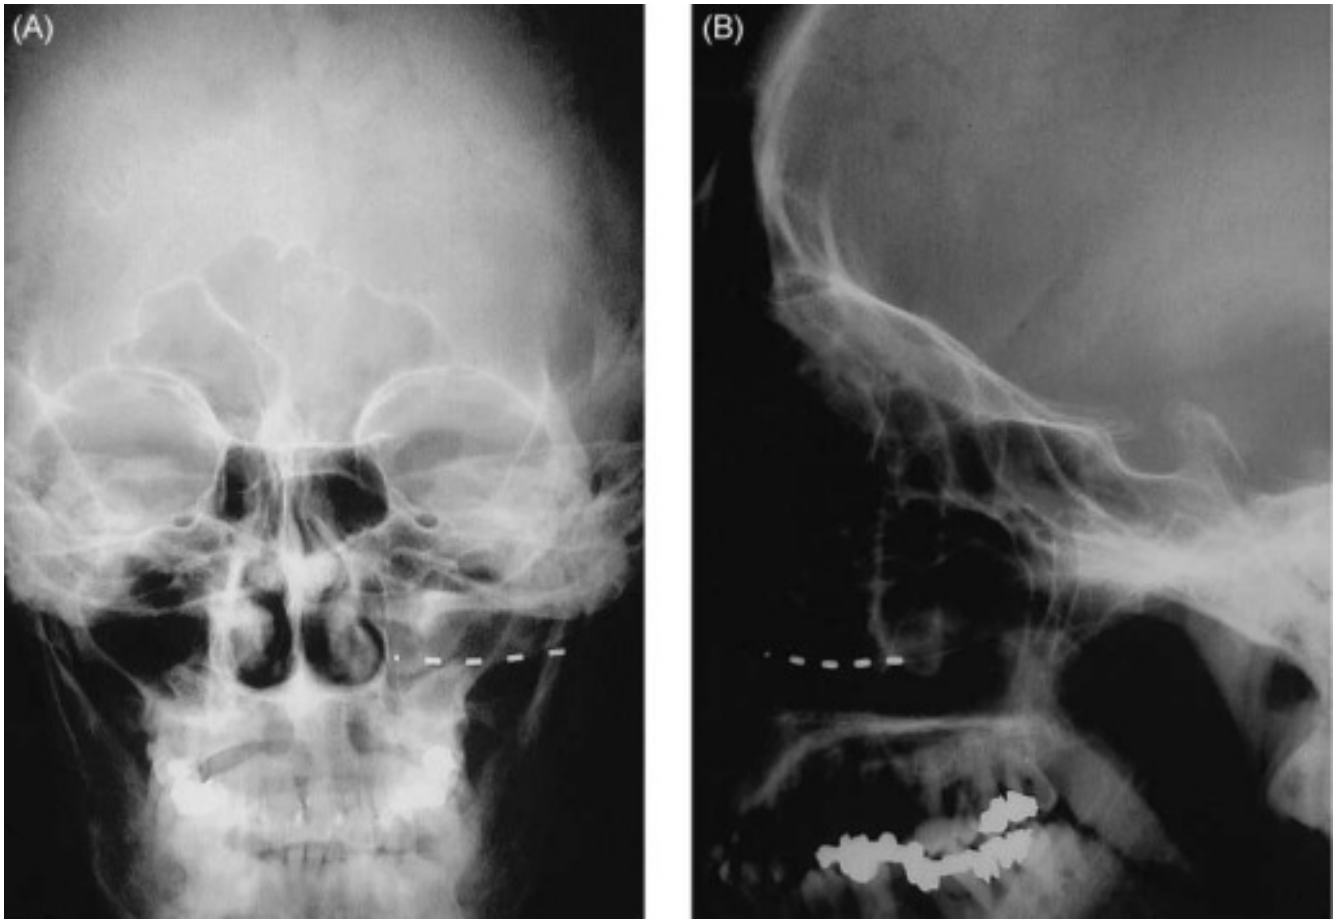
Radiographs of the infraorbital electrode (A, anteroposterior; B, lateral).
